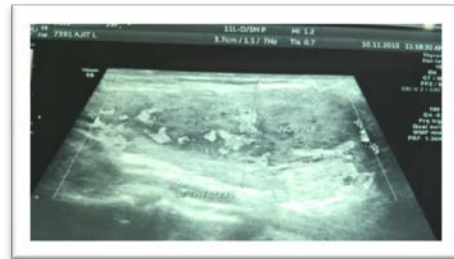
Ultrasound film of thyroid gland.
